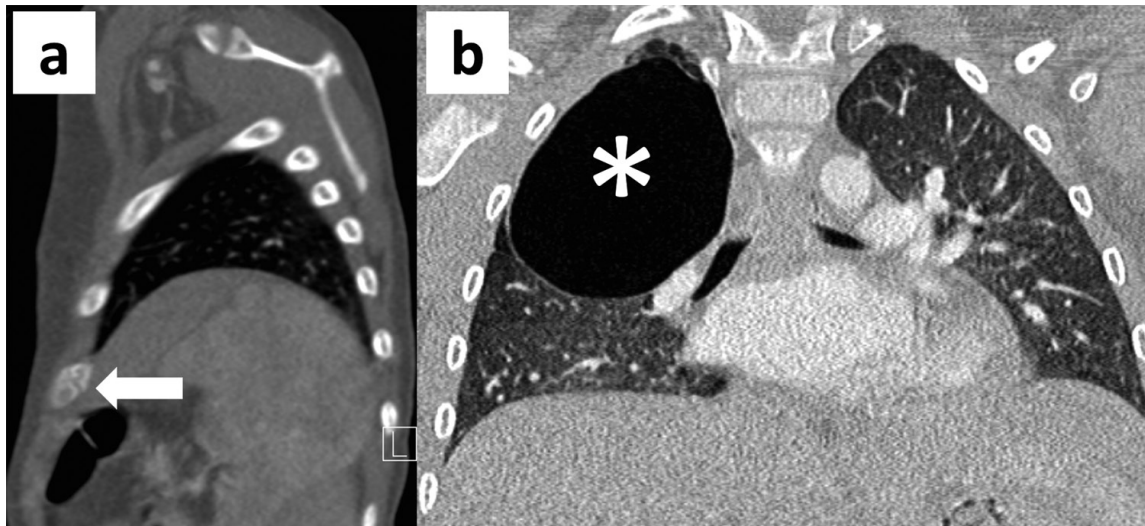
Enhanced CT of the chest. a) Sagittal reformats in bone window showing a rib fracture (arrow). b) Coronal reformats showing right upper lobe pneumatocele (asterisk).
